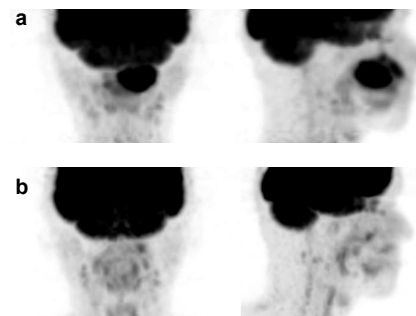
(a) Fluorodeoxyglucose positron emission tomography scan of the oral cavity prior to salvage therapy. FDG uptake was shown in the tumor. (b) Fluorodeoxyglucose positron emission tomography scan of the oral cavity after autologous stem cell transplantation. No abnormal uptake was present in this region.
